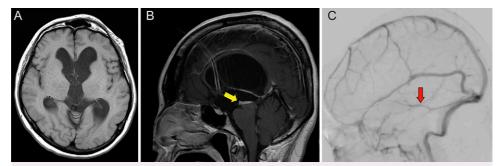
A: Preoperative axial T1-weighted MR image showing that the bilateral temporal homs and third ventricle are dilated. The Evans index is 0.44. B: Preoperative sagittal T1-weighted contrast-enhanced MR image. The DVA directly above the cerebral aqueduct is observed as the abnormal distended linear region with enhancement (*yellow arrow*). The fourth ventricle is not dilated. An enhancing structure within the frontal horn is aliasing. C: Preoperative digital subtraction angiography shows a mesencephalic DVA (*red arrow*).
